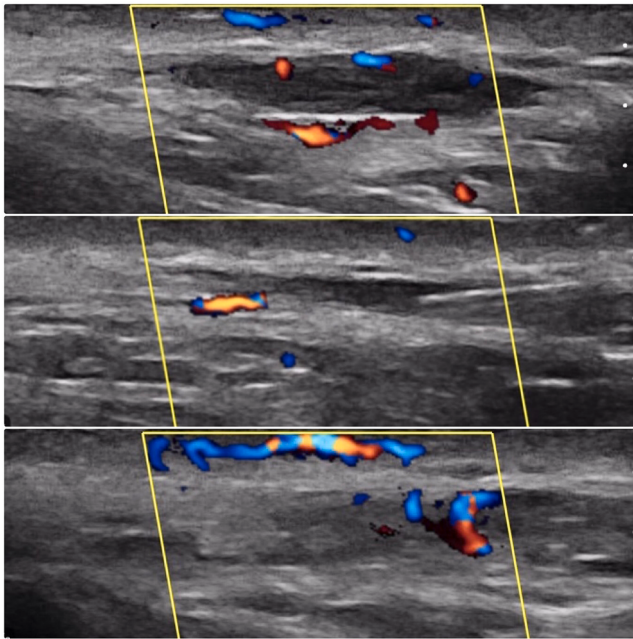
An example of color Doppler ultrasound use in a vascular occlusion caused by HA filler. Top: full occlusion and dilation of the vessel; middle: partial occlusion and recovery of the thickness of the vessel; bottom; full recovery of the flow and thickness of the vessel.
